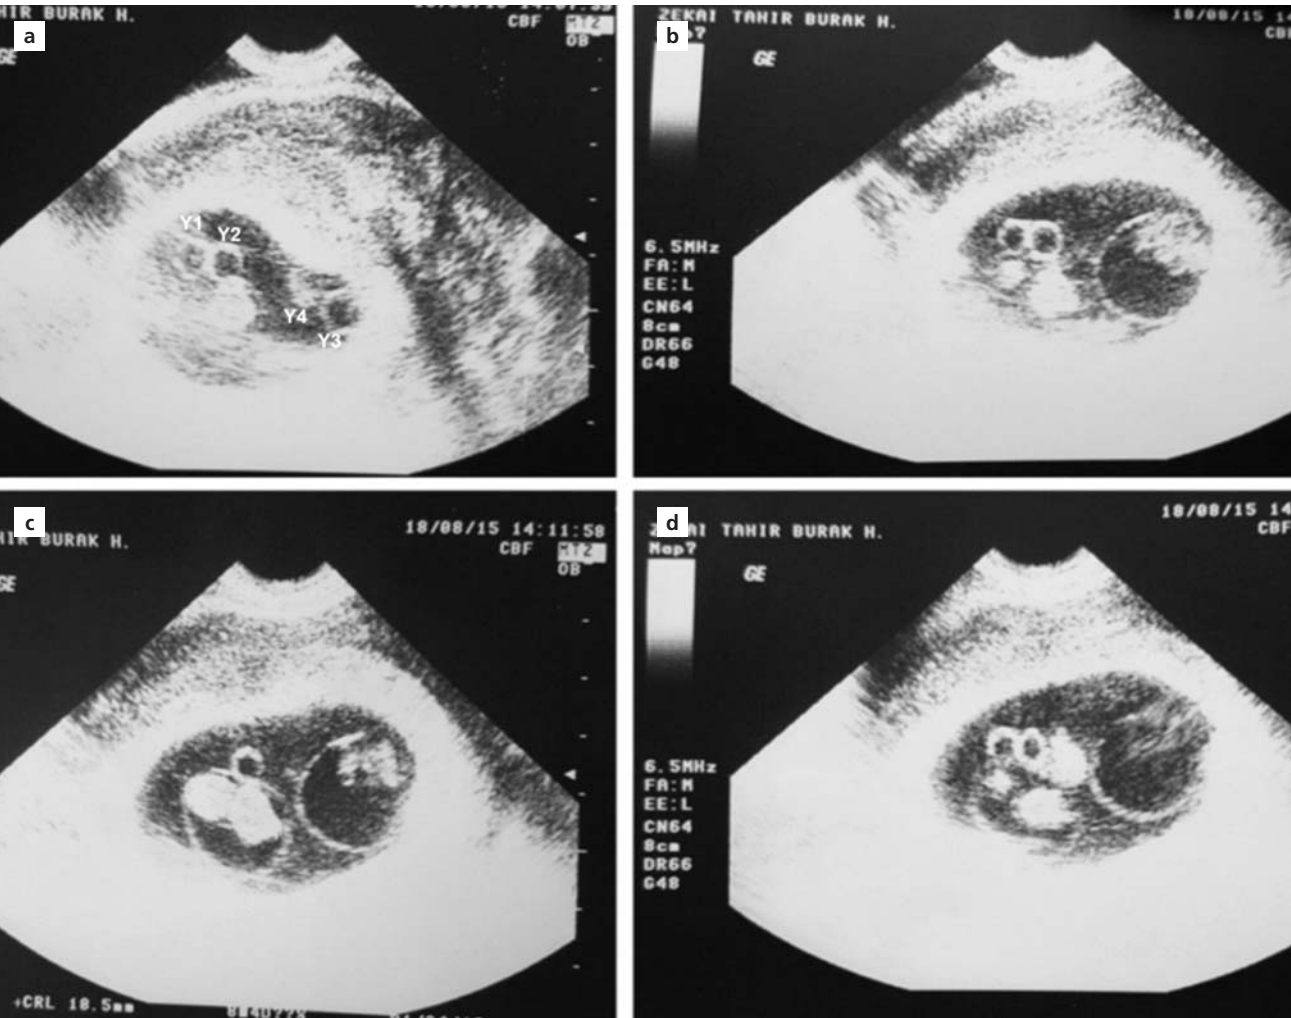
(a-d) Transvaginal ultrasonography of pregnancy at 84/7 weeks: Four fetuses in gestational sac (monozygotic quadruplets; four of them cannot be seen in the same image).
